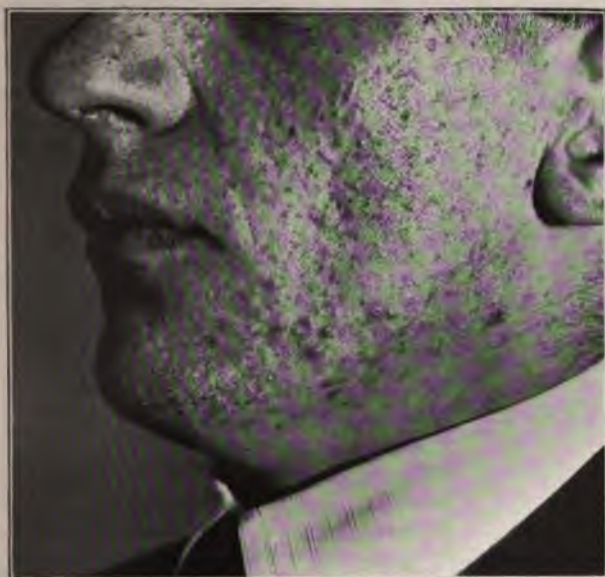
Comedo before x-ray treatment.
